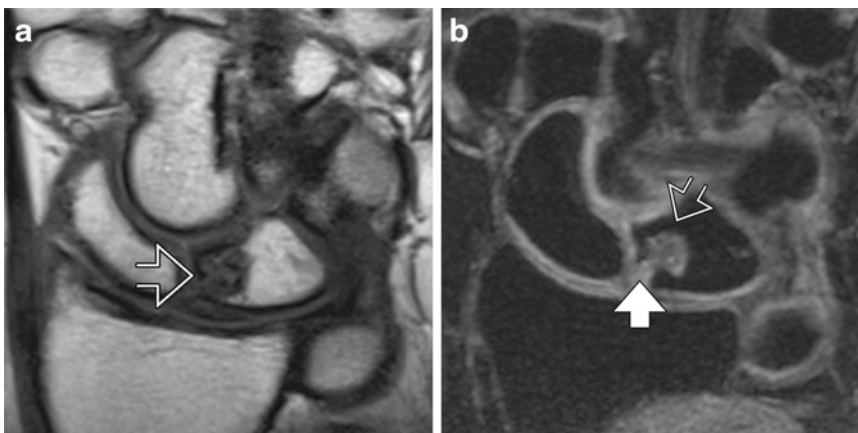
Intraosseous ganglion cyst within the lunate. (a) Coronal T1-weighted MR image shows a well-defined area of hypointensity in the radial aspect of the lunate (arrow). (b) Coronal T2-weighted fat-suppressed image
